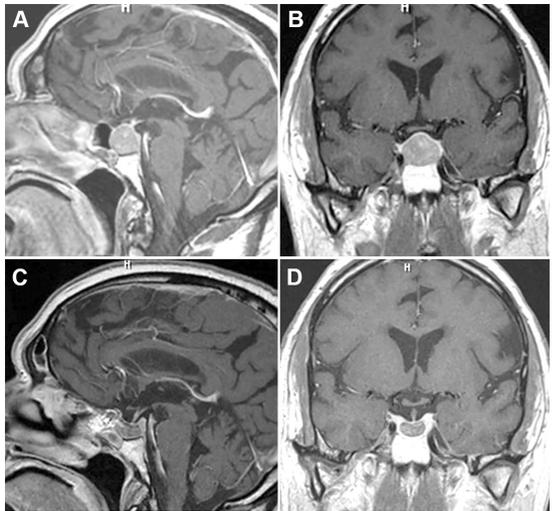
A man in his early 60s presented with acromegaly. Combined transsphenoidal approach was performed. Preoperative (A) sagittal (B) coronal post-contrast T1 MRI of the head shows intra, and supra-sellar tumor with intratumoral hemorrhage and compression of optic chiasm. Postoperative (C) sagittal and (D) coronal post-contrast MRI of the head shows complete resection of the tumor with intact pituitary gland/stalk. Visual symptoms recovered with remission of acromegaly.
